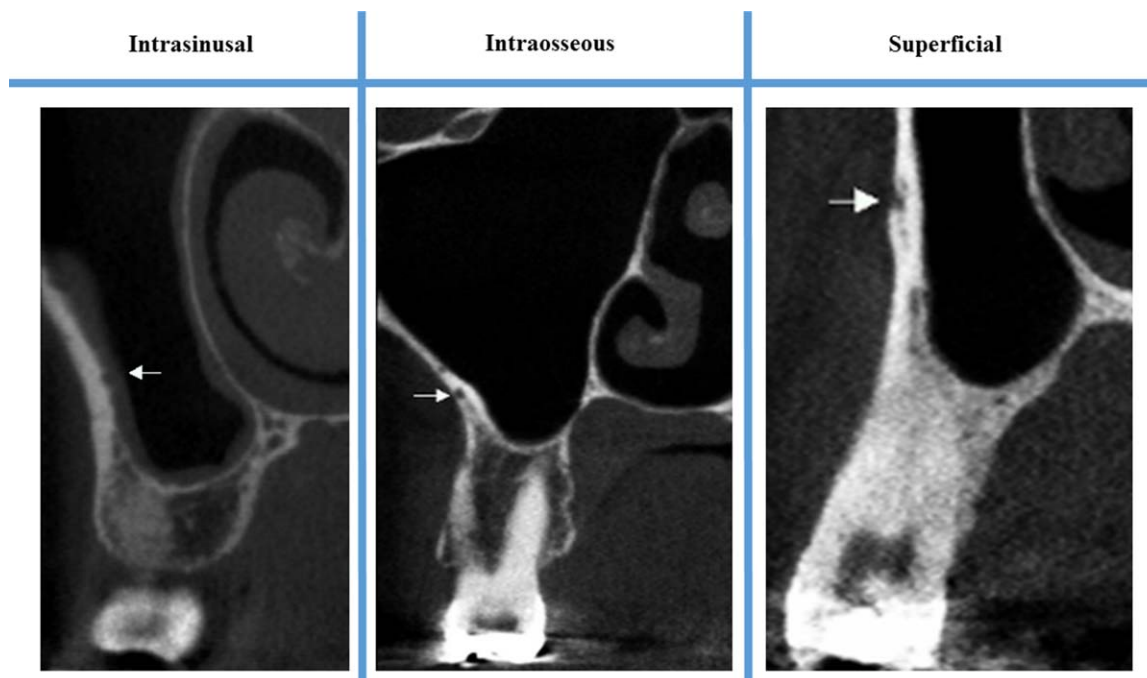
Transverse view of the CBCT scan of a sinus showing PSAA below the Schneiderian membrane (intrasinusal), inside the bone (intraosseous), and on the outer cortex of the lateral sinus wall (superficial).
